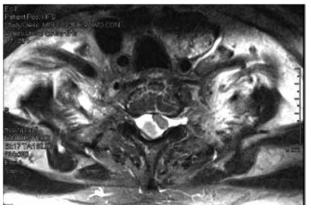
Transverse T2-weighted image at T_1 - T_2 showing right posterolateral tumor with mass effect and cord compression.
